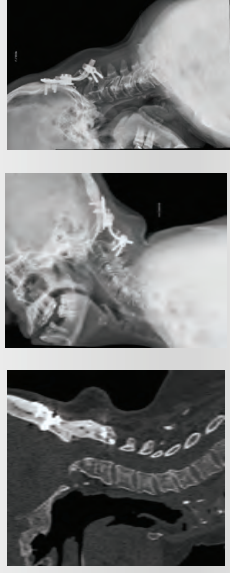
CT scan and dynamic X-ray demonstrating graft integrity and fusion of the segment at 1 year postop.
